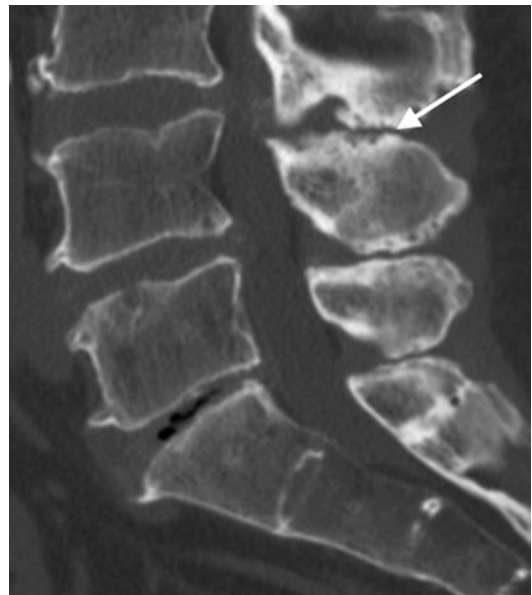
Degenerative disc disease on reformatted Sag CT, bone windows, demonstrating loss of disc height, vacuum phenomenon, minor endplate osteophytosis L5–S1. Less pronounced degeneration at L4–5. Note imaging features of Baastrup disease, contacting adjacent spinous processes demonstrating cortical irregularity and sclerosis (*arrow*)
